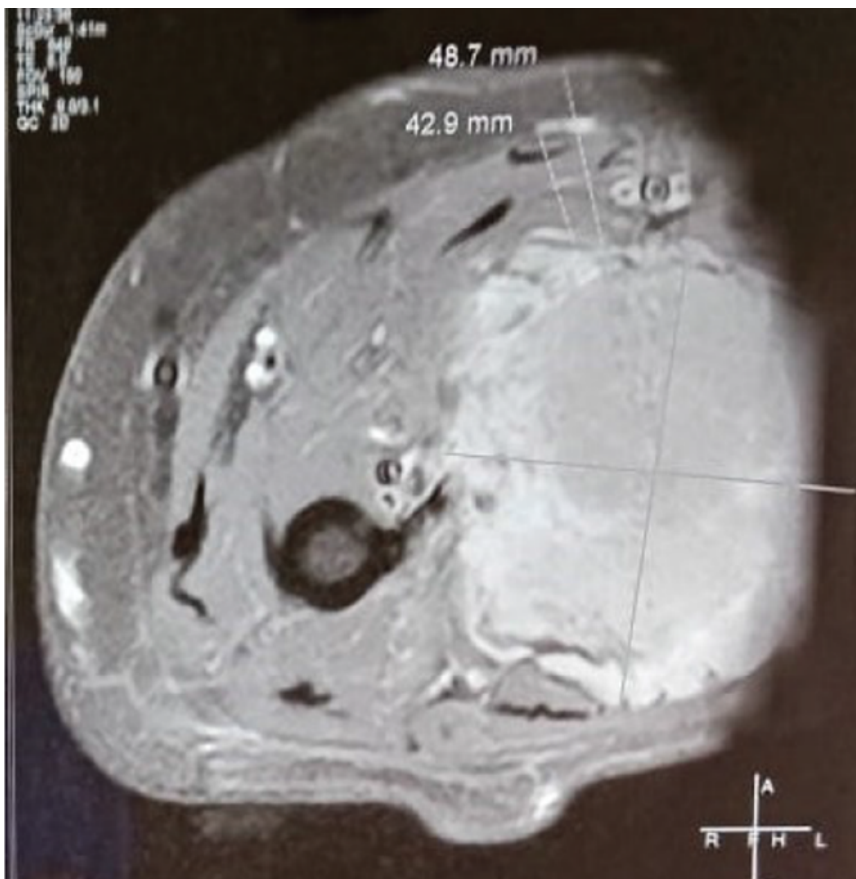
MRI of left forearm arm.
